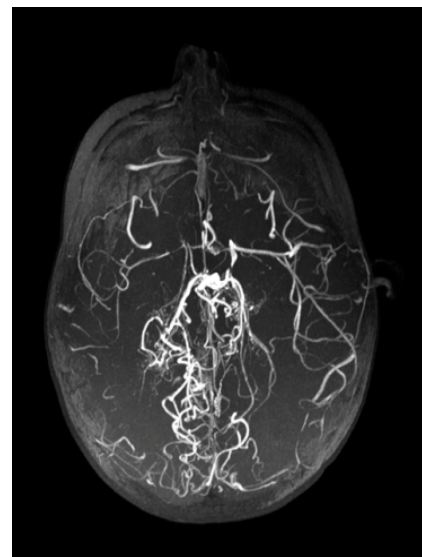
Multimodal Neuroimaging - MRI, SPET in a case of hemiplegic migraine. Fig.12b: angio MRI for study of moya-moya. (Figs.12 a,b,c all courtesy of Prof. D. Cecchin-Nuclear Medicine-Padua).
